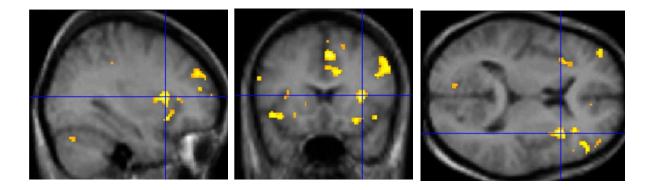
Functional magnetic resonance imaging showing cerebral activations correlated with the experience of strong air hunger in healthy subjects. Strong activation is shown in the right interior insula, but also left anterior insula, anterior cingulate, supplementary motor area, prefrontal cortex and cerebellum. Most regions are categorised as limbic/paralymbic, and overlap with activations seen with pain, thirst, fear and hunger (Evans *et al.*, 2002).
